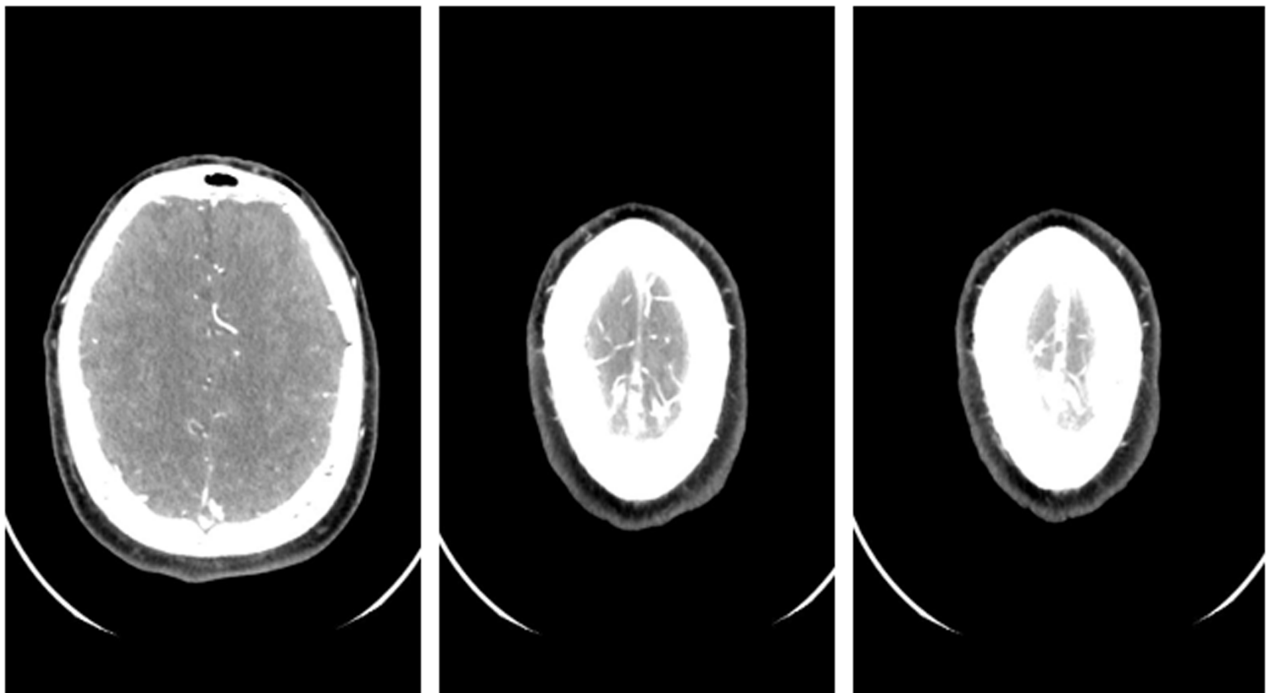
Radiological images from cranial CT Angiography conducted during hospitalization showing irregular uptake at superior sagittal sinus, compatible with thrombosis.
